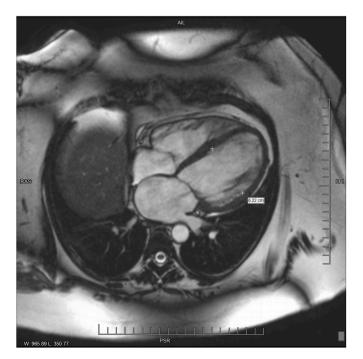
Cardiac MRI. 4-chamber view of the heart shows dilatation of the left and right ventricles with mitral and tricuspid regurgitation jets.
